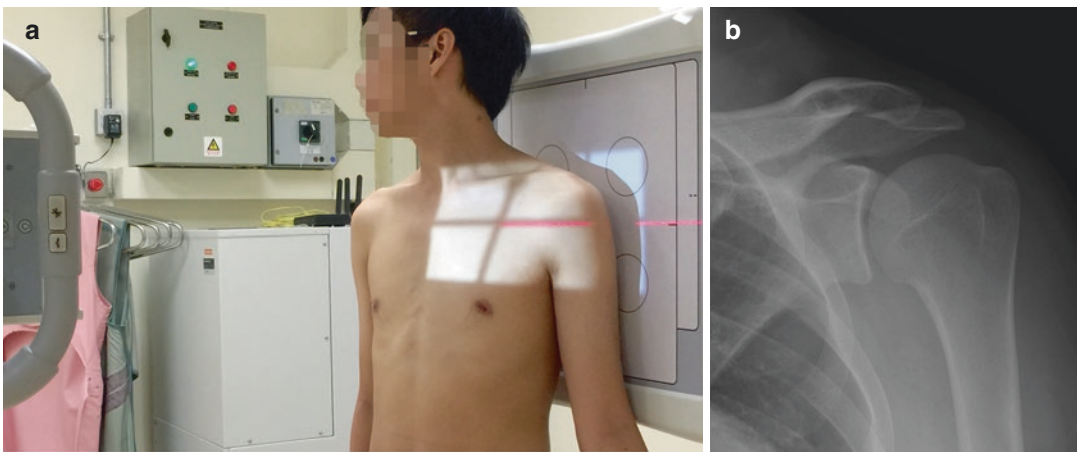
(a) Radiographic positioning for Grashey view (b) The Grashey view provides a tangential view of the glenohumeral joint (radiograph courtesy of Dr. Bill Morrison)
